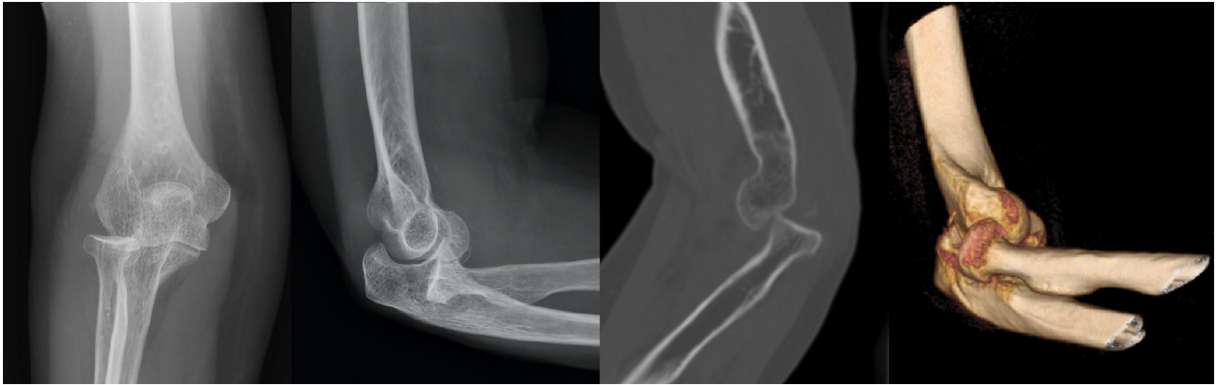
X-Ray and CT scan (sagittal view and 3D reconstruction) of the right elbow, performed in the emergency department, showing a posterior isolated radial head dislocation, no evidence of fractures or other concomitant injuries.
